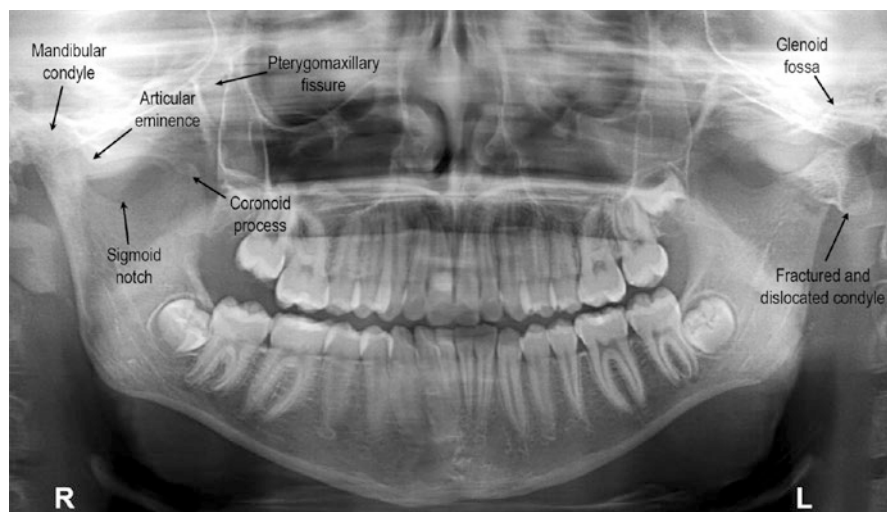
Panoramic radiograph of a patient with a left condylar neck fracture with medial condylar displacement. The patient’s right side displays normal anatomy—condyle, articular eminence, sigmoid notch, coronoid process, and pterygomaxillary fissure. The left glenoid fossa is also labeled (Courtesy Dr. Don Tyndall, Oral and Maxillofacial Radiology, UNC School of Dentistry, Chapel Hill, North Carolina)
